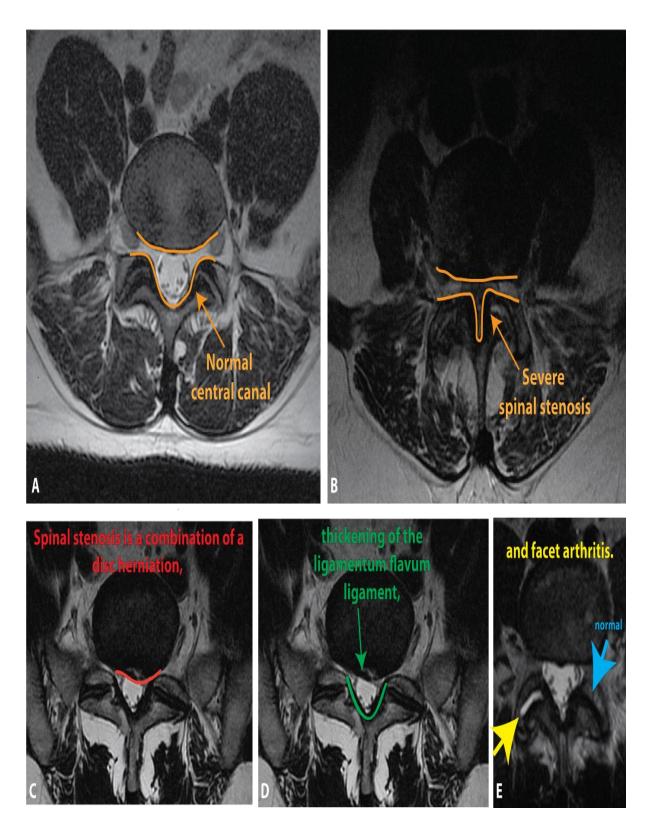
MRI showing spinal stenosis
